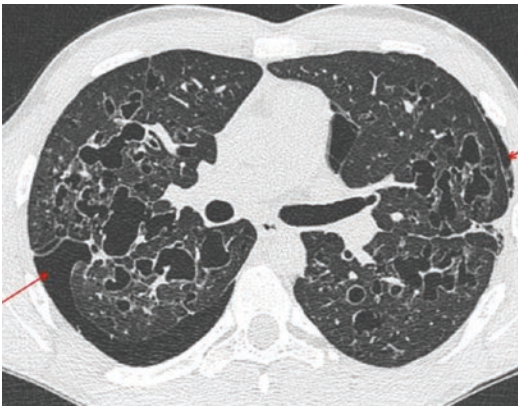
HRCT: More advanced disease with predominant cysts of variable size and irregular shapes (“bizarre cysts”). Note the presence of bilateral partial pneumothorax (arrows)
